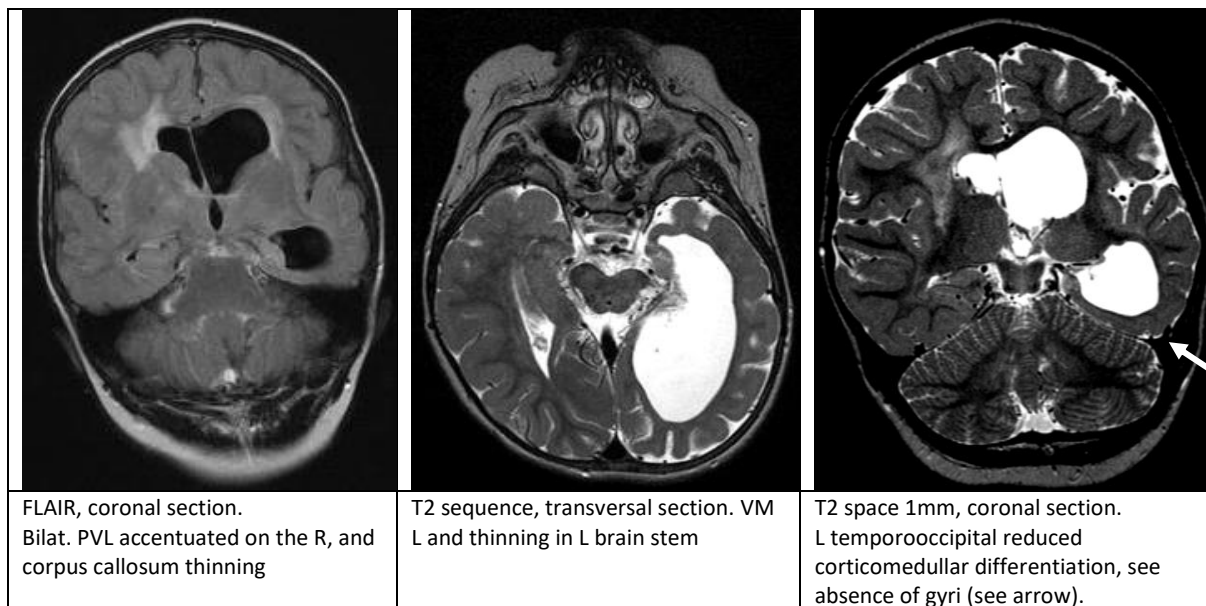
Preoperative MRI, Pat. 1, at age two years and six months.
